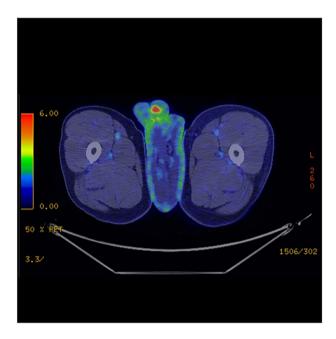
FDG-PET CT image. Signal accumulation was observed at the root of the penis.
